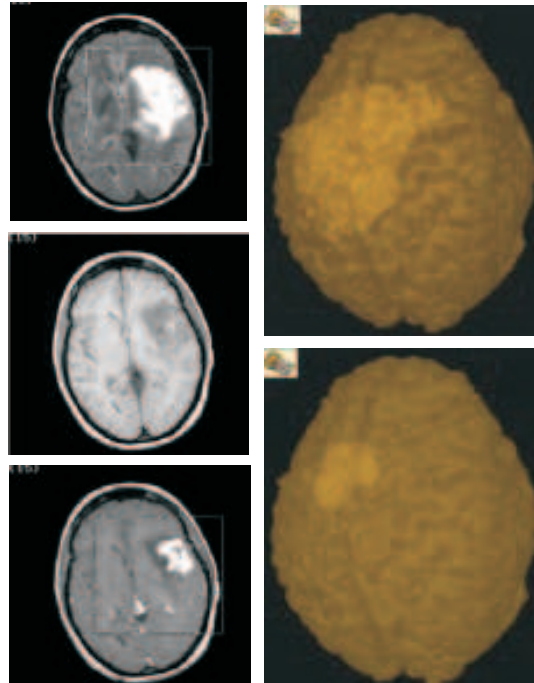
Tumor segmentation. Left column: FLAIR and T1 weighted MRI without and with contrast agent; Right column: The edematous tumor region segmented via AFC from the FLAIR image and from the subtracted (post from pre-contrast) image showing enhancing aspects of the tumor.
